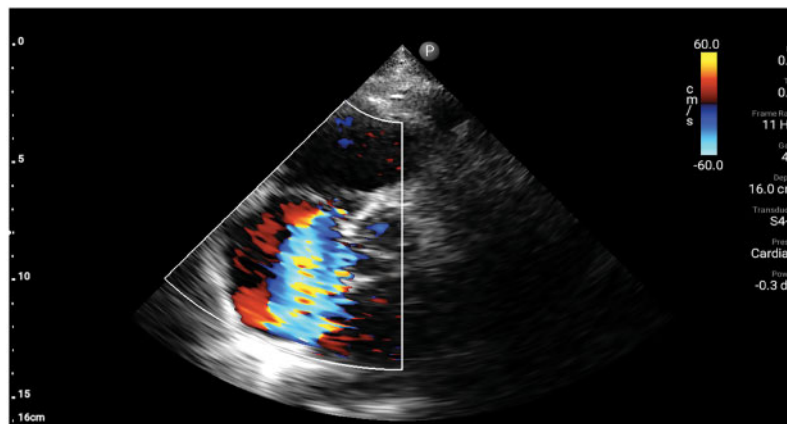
Parasternal short-axis view with moderate tricuspid regurgitation.
